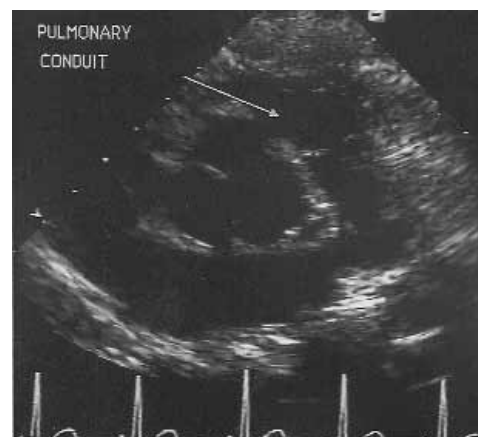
Late (16 months after Ross operation) postoperative echocardiogram in a 10-year-old child showing the valve within the right ventricular-pulmonary arterial conduit.
